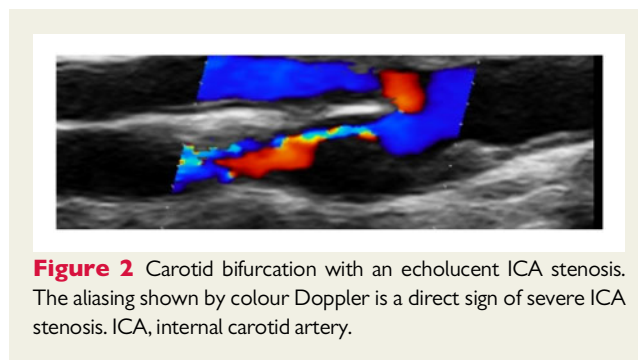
Carotid bifurcation with an echolucent ICA stenosis. The aliasing shown by colour Doppler is a direct sign of severe ICA stenosis. ICA, internal carotid artery.
